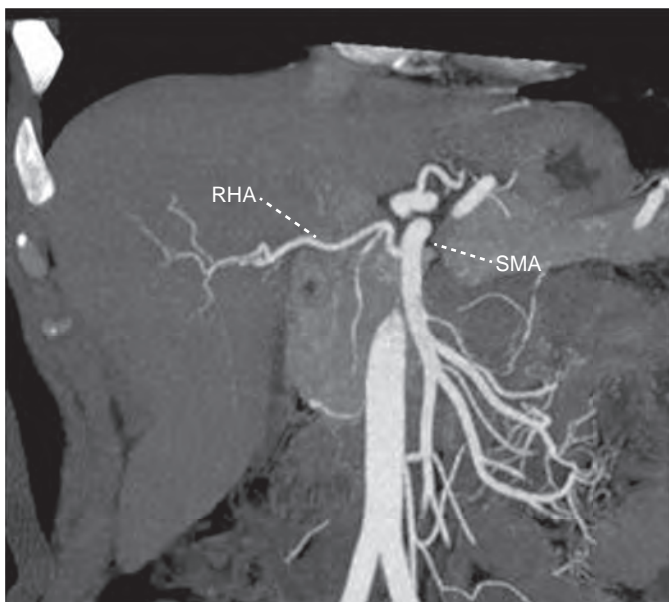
CT angiogram of a liver donor patient (body weight, 74 kg) at 100 kVp tube potential still provides good delineation of arterial mapping. Use of a low peak kilovoltage approach over the standard 120 kVp can attain dose reduction of up to 20% to 30%. RHA, Right hepatic artery; SMA, superior mesenteric artery.
